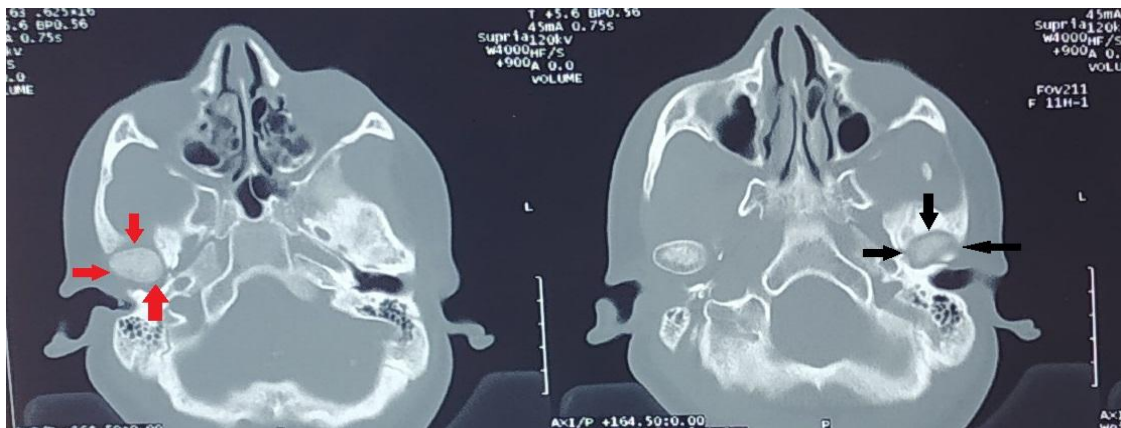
3D-computed tomography picture showing uniform enlargement of the right condylar head (red arrow)
